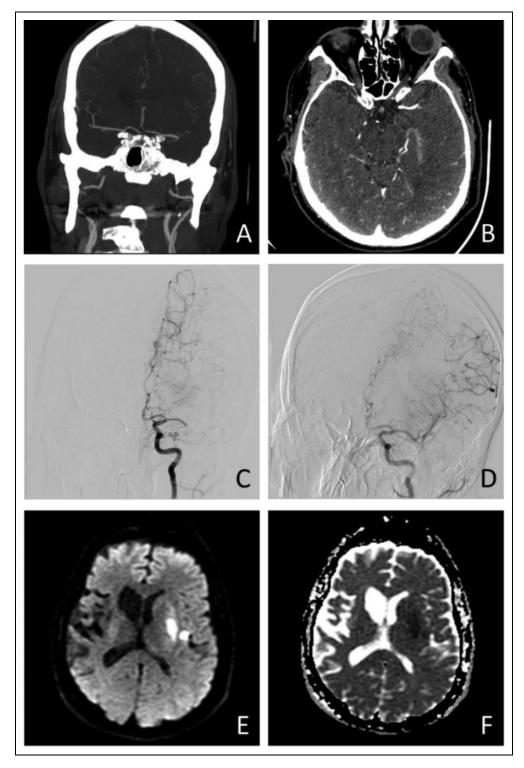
A and B, Computed tomography angiography coronal (A) and axial (B) views demonstrating left mid MI occlusion. C and D, Angiographic anteroposterior views of pre (C) and post (D) thrombectomy showing thrombolysis in cerebral infarction 2a revascularization of the left MI segment with delayed perfusion to a small caliber M3 insular branch. E and F, Magnetic resonance imaging diffusion-weighted imaging (E) and apparent diffusion coefficient (F) sequences demonstrating patchy regional infarctions involving the left lentiform and caudate nuclei with smaller foci involving the left frontal and temporal opercula. Right cerebral hemisphere encephalomalacia from the previous stroke is also demonstrated.
